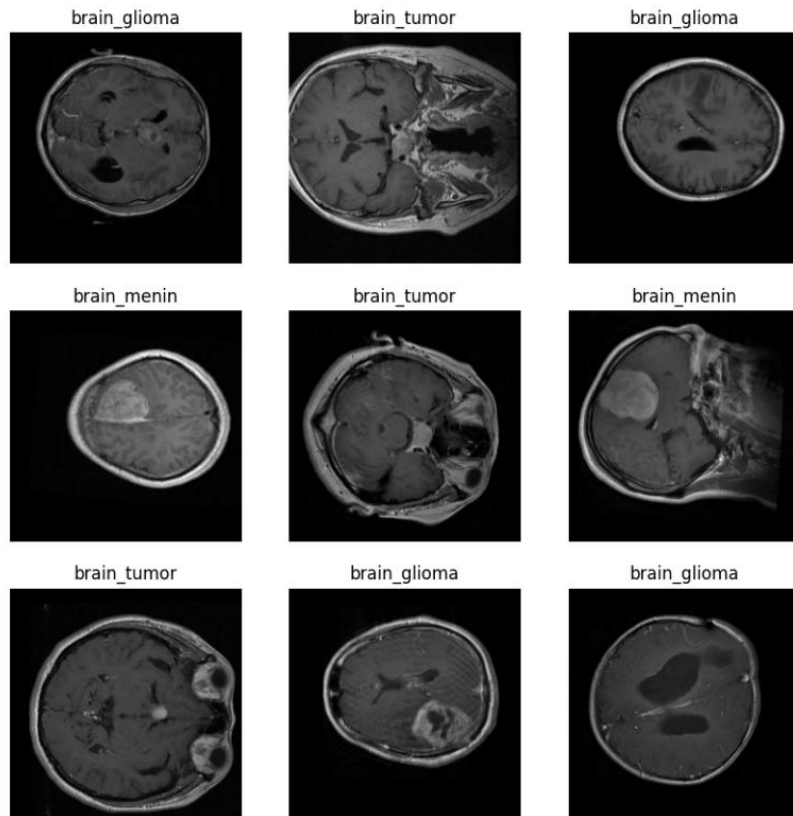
Brain Cancer MRI Dataset
